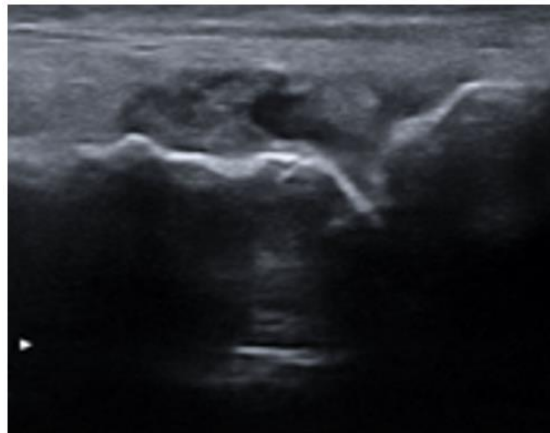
Ultrasound view of numerous tophi on a dorsal scan of a metatarsophalangeal joint
